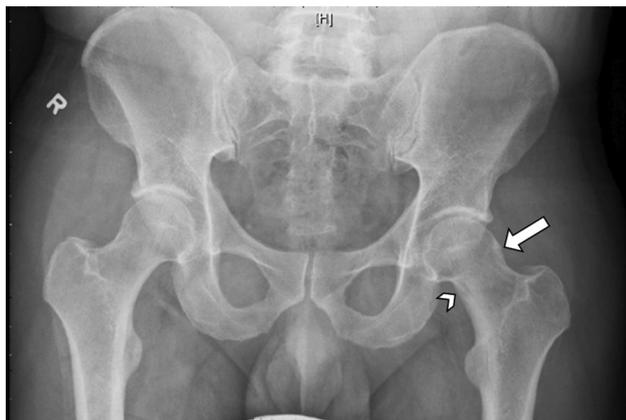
Pre-operative X-ray showing Cam lesion and medial femoral neck thickening (*arrow*) characteristic of FAI; the nidus on the medial femoral neck (*chevron*), which was missed initially, can also be discerned radiographically
